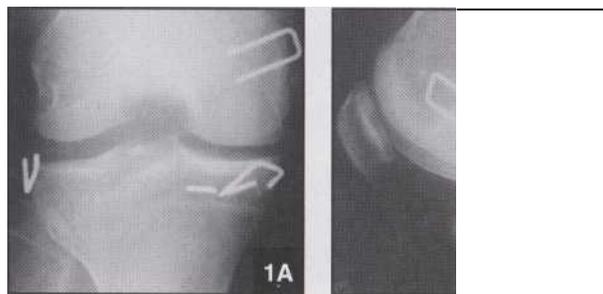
Preoperative AP radiograph, demonstrating staple fragments within 15 mm of medial joint line and loose fragment laterally (A). Preoperative lateral radiograph demonstrating loose fragment in posterior knee (B).
